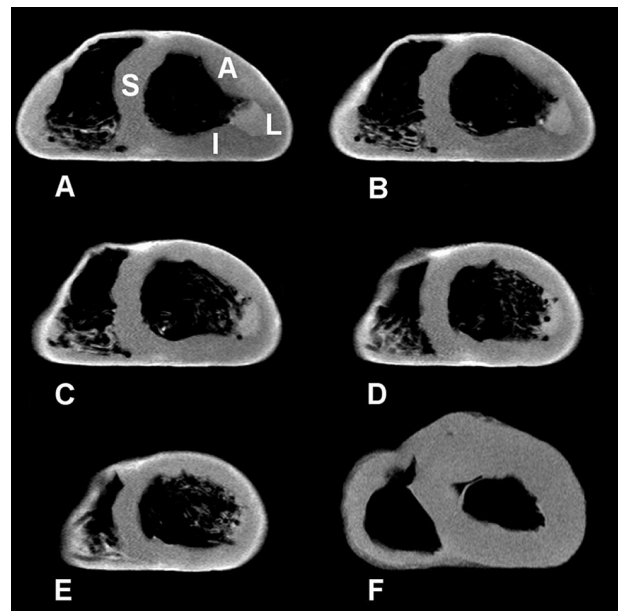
Short-axis T1-weighted MR images of excised hearts. (A–E): Representative slices of a heart excised 3.5 hr following intrapericardial infusion of Gd-DTPA. The bright, uniform ring of enhancement around the epicardial surface is the result of decreased T1 relaxation time due to Gd-DTPA penetration. No enhancement is seen along either side of the interventricular septum (S). (F): By comparison, the control heart, with saline only, shows no contrast rim at 8 hr after intrapericardial saline. L = lateral wall, A = anterior wall, I = inferior wall, S = septum.
